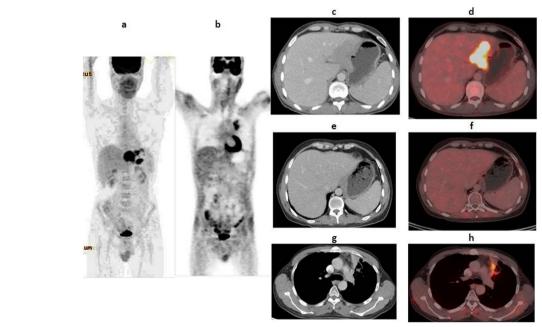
A 35-year-old male patient, newly diagnosed case of gastric lymphoma. Initial PET/CT study including whole body PET MIP (a), axial CECT (c), and corresponding fused PET/CT (d) images revealed irregular hypermetabolic gastric soft mass infiltrating the related left hepatic lobe and achieving 22.8 SUL_{peak}. Follow-up PET/CT study revealed complete resolution of the mass in whole body PET MIP (b) as well as axial CECT (e) and corresponding fused PET/CT (f) images denoting CR and CMR according to RECIST 1.1 and PERCIST 1.0, respectively. However, the whole body image (b) showed another newly developed metabolically active lesion at upper lobe of left lung that was a pneumonic consolidative patch in axial images (g) and (h).
